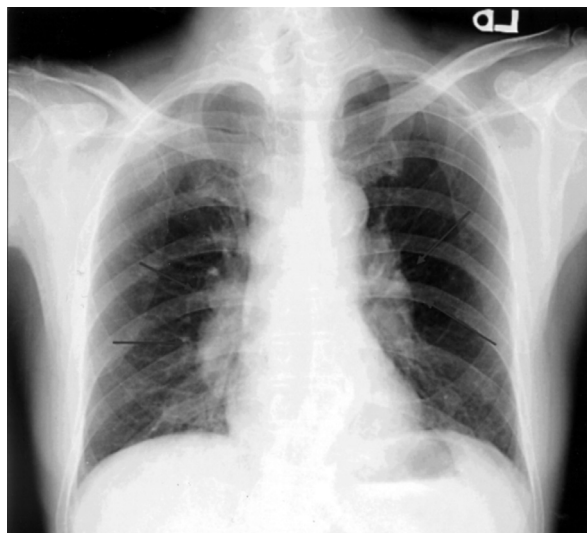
Chest radiograph revealing bilateral hilar lymphadenopathy enlargement (red arrows)
